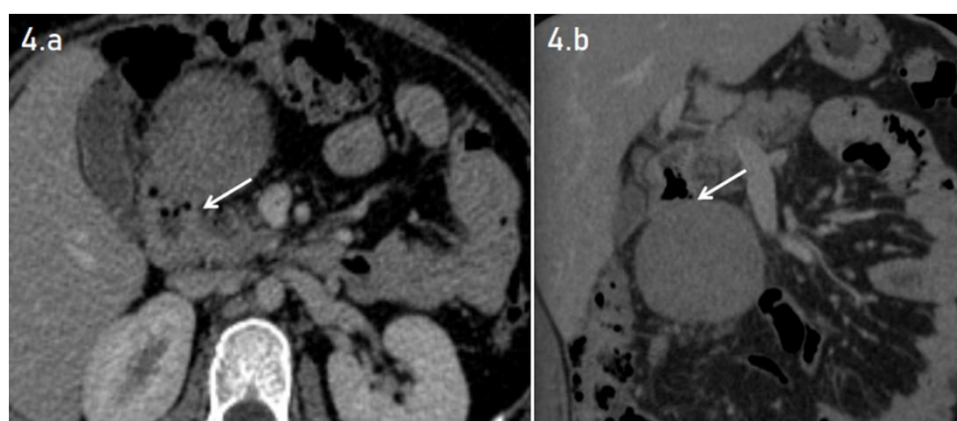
(a & b): 37-year-old case with benign duodenal GIST. Axial (a) and coronal (b) views of contrast-enhanced CT study of abdomen in venous show a well-defined ovoid soft tissue density lesion (solid arrow) arising from the second and third parts of the duodenum. The lesion is seen to arise exophytically without causing any upstream bowel dilatation.
